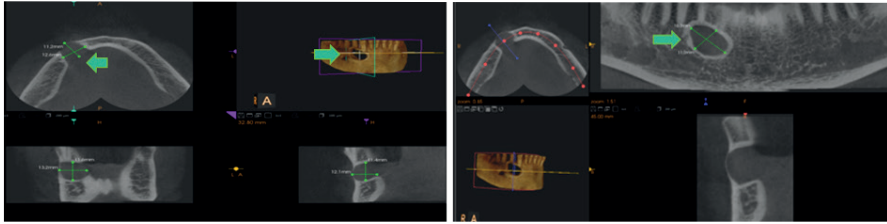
CBCT image of the first examination
